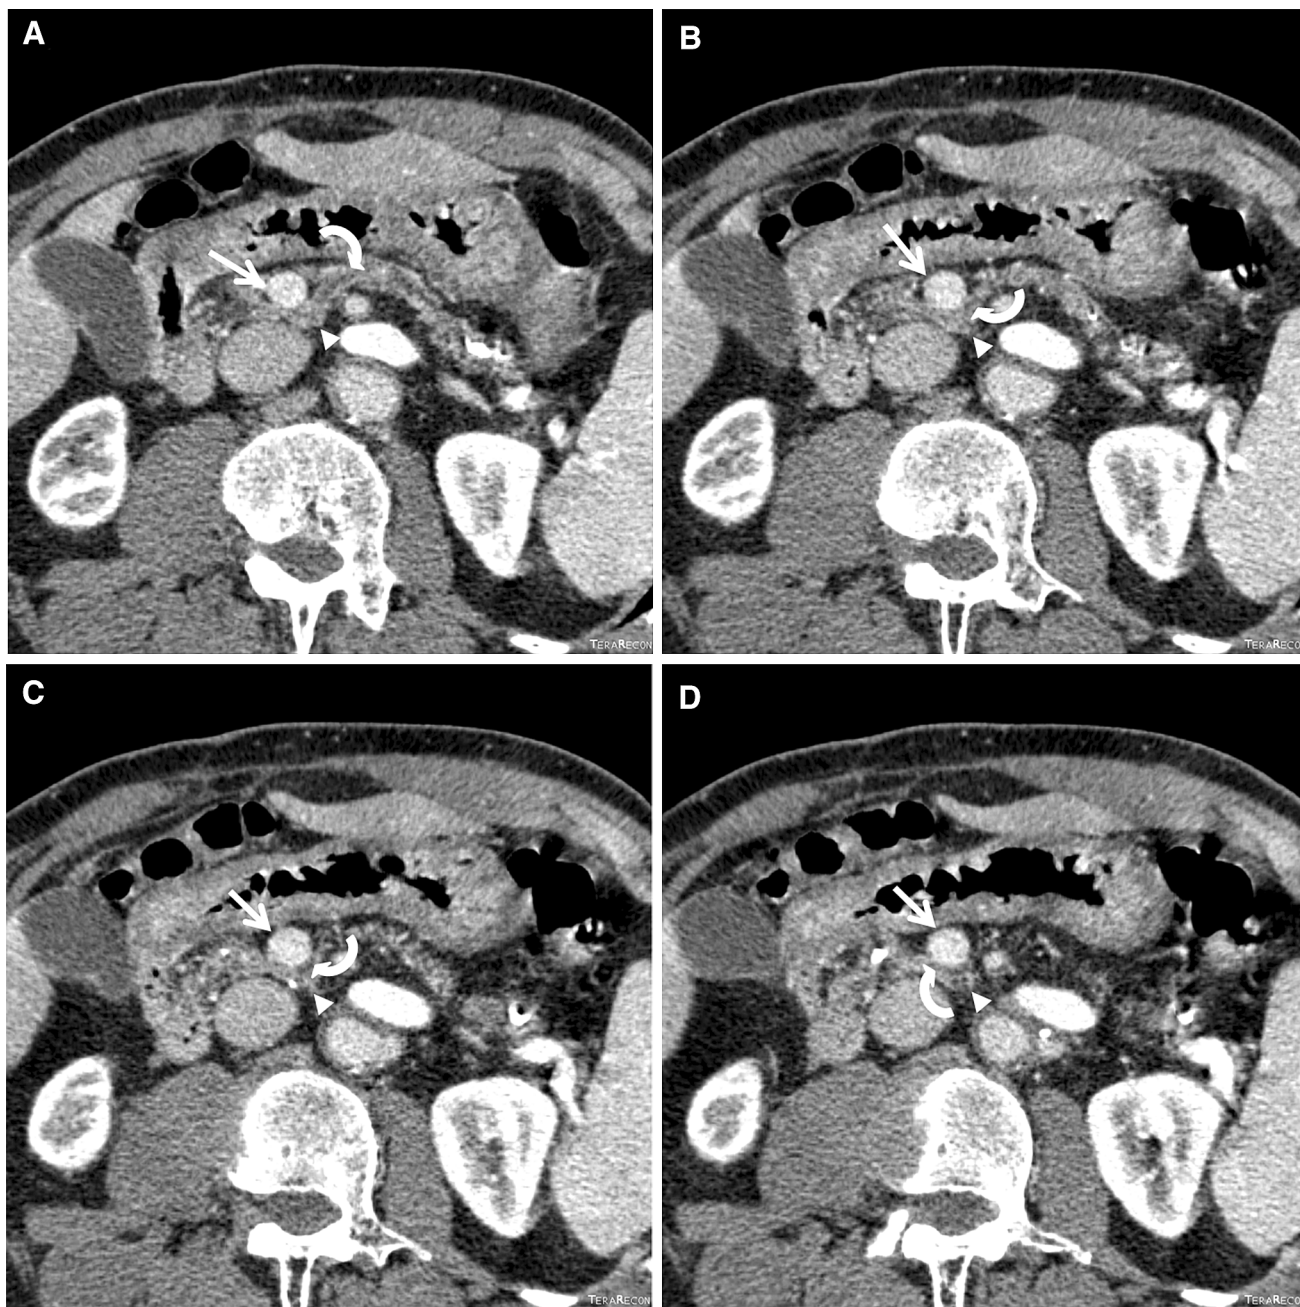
Infraplenic circumportal pancreas with retroportal duct in a 69-year-old man. Oblique axial post-contrast CT images cranial to caudal (A–D). Main pancreatic duct (curved arrow) courses posterior to the SMV (white arrow)
